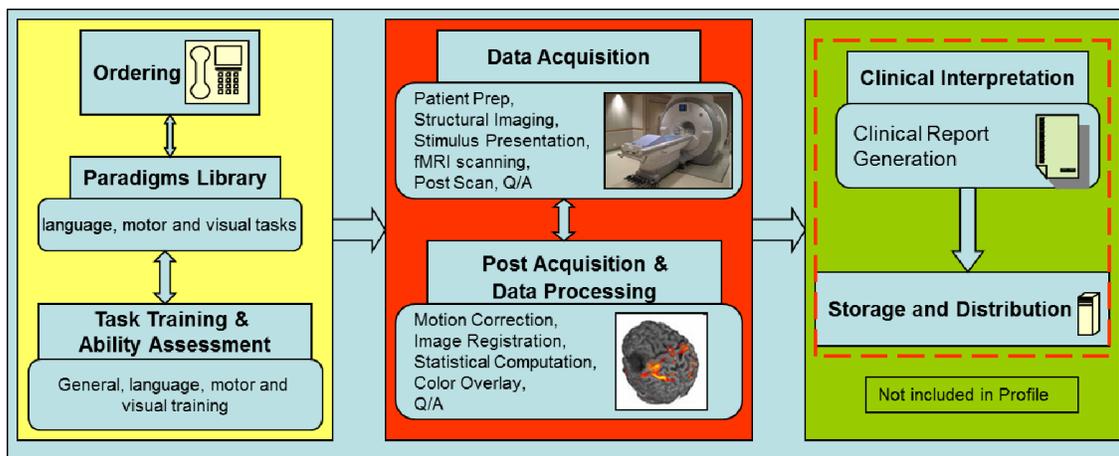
Mapping of Brain Regions using Blood Oxygenation Level Dependent (BOLD) functional MRI as a Presurgical Assessment Tool – Activity Sequence.
